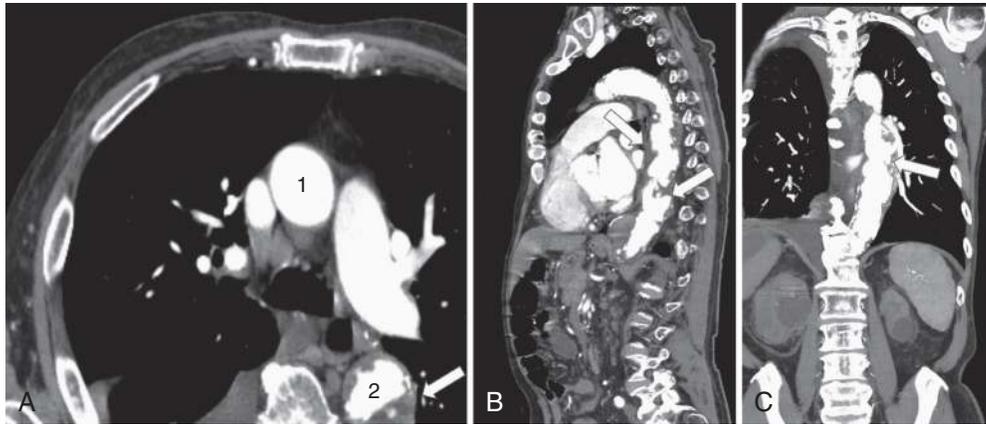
CT angiography demonstrating heavily diseased thoracic aorta (“shaggy aorta”). The arrows show atherosclerotic plaques. The difference between a normal vessel and a severely atherosclerotic one can be appreciated here in A, between the ascending aorta (1) and the descending aorta (2). A, Transversal view; B, sagittal view; C, coronal view.
